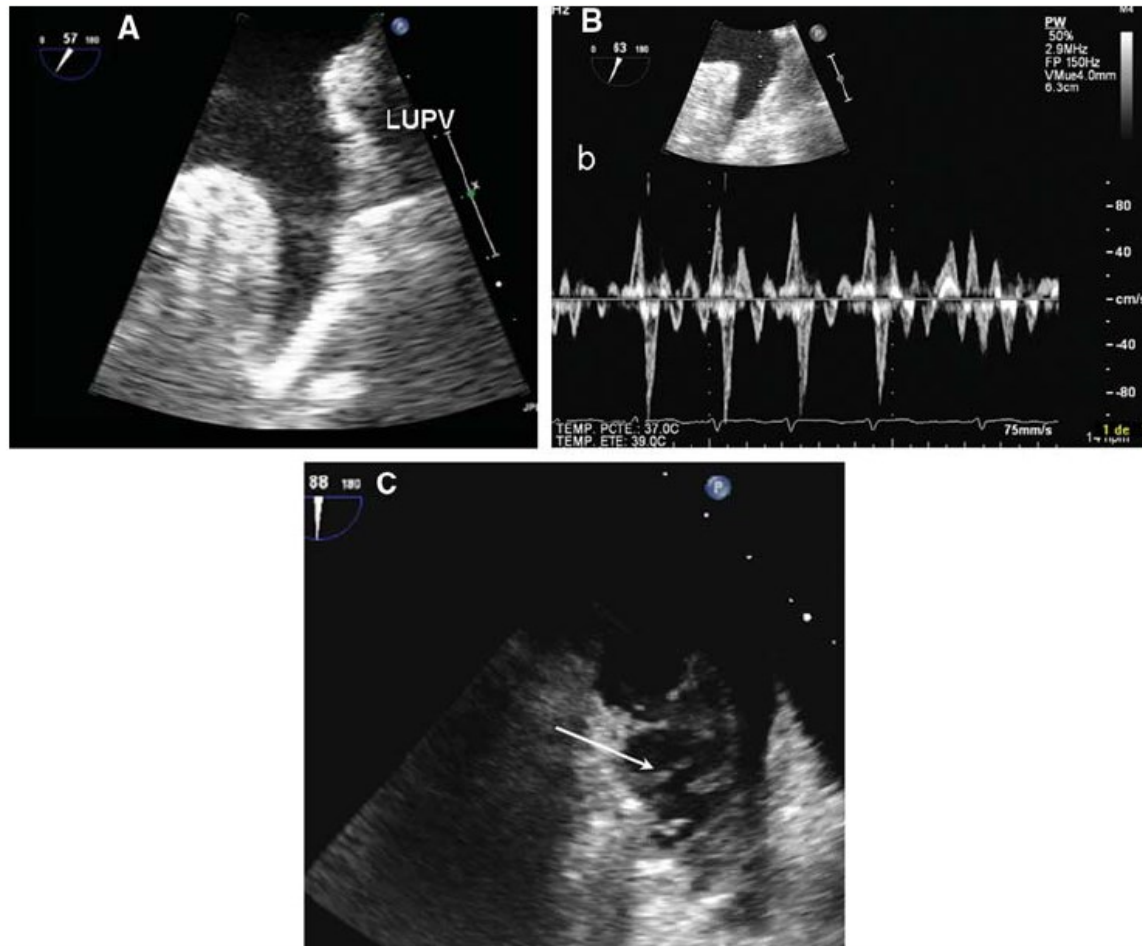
(A) Left atrial appendage. (B) Pulsed wave Doppler recording of emptying (upward) and filling (downward) velocities in atrial fibrillation. The velocities are quite high (>25 cm/s), indicating relatively low risk of thrombus generation. LUPV, left upper pulmonary vein. (C) Example of left atrial appendage with marked pectinate muscles (arrow). There is no thrombus.
